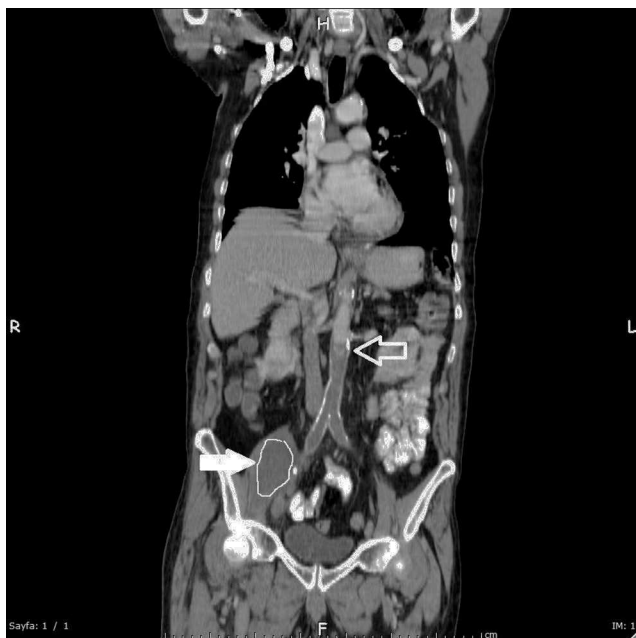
In the coronal section of the oral and intravenous contrast-enhanced abdominal CT; initial localization of the infrarenal occlusion in the abdominal aorta (hollowarrow), a hypodense heterogeneous abscess leading to expansion of right psoas muscle (arrow).
